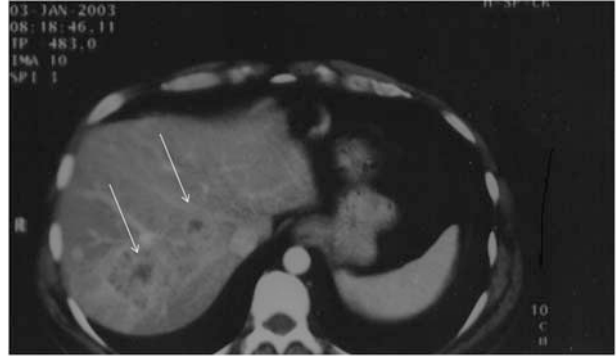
Computed tomography scan from January 3, 2003, shows stable hepatic parenchymal lesions as compared to October 8, 2002 (arrows).
